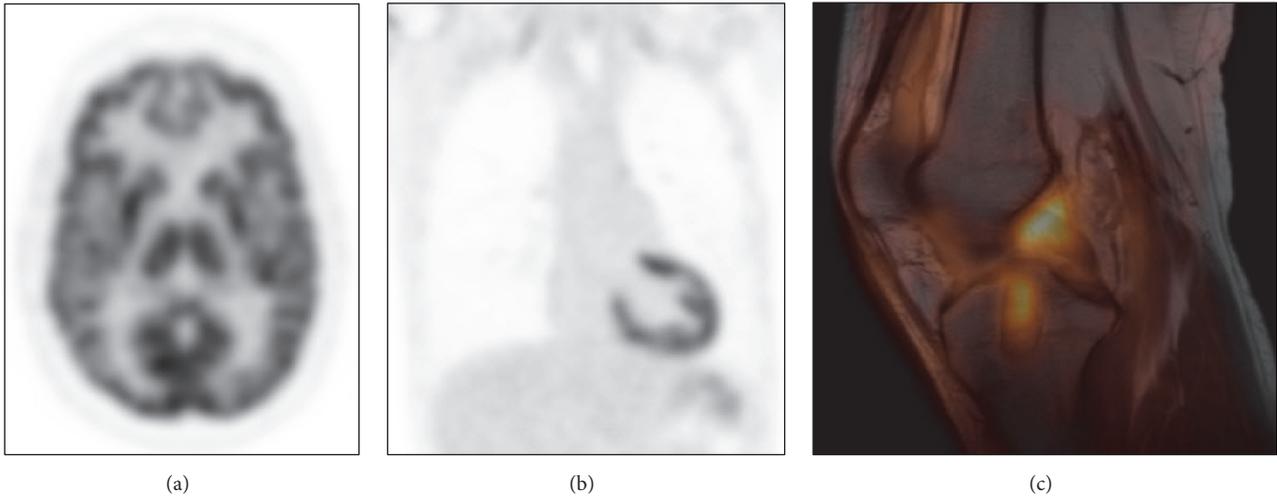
Nononcologic clinical opportunities for lower dose/higher definition imaging enabled by next-generation dPET include (a) neurologic, (b) cardiovascular, and (c) orthopedic/sports medicine indications. Digital PET cases demonstrated were imaged using standard ^{18}F -FDG doses of 448 MBq and 477 MBq for (a) and (b), respectively, and ultralow ^{18}F -FDG dose of 100 MBq for (c). The dPET acquisitions were obtained at 55 min after injection for (a), 53 min after injection for (b), and 60 min after injection for (c). The dPET emission scans were acquired with 90 s per bed position for (a) and (b) but (c) was a limited single bed acquisition for 15 min. Low dose CT attenuation scans were acquired using 120 kV and 50 mA with dose modulation and using iterative iDose⁴ reconstruction.
